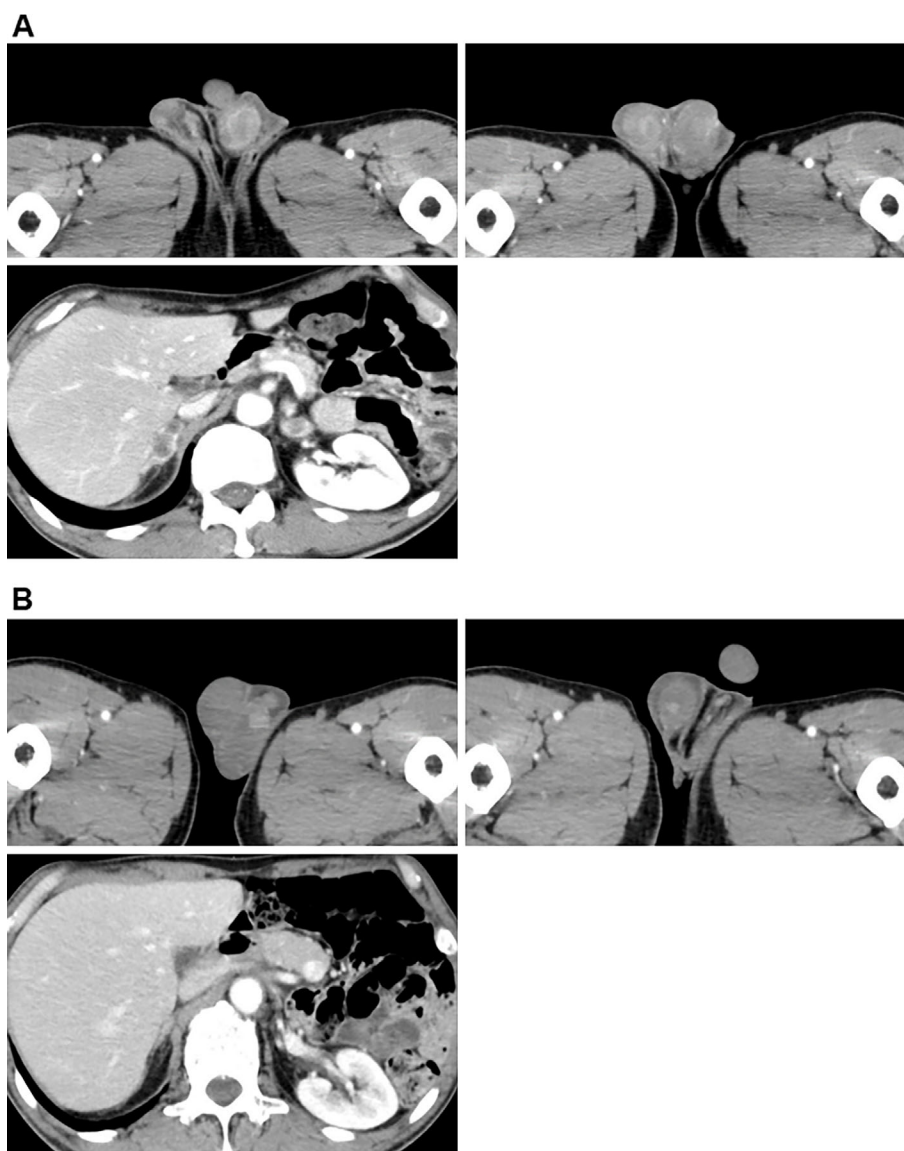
(A) A radiographic review of the patient's contrast abdominal and pelvic CT scans performed in September 2017 incidentally revealed bilateral testicular and adrenal gland masses. (B) When reviewed retrospectively, the CT scan performed in May 2017 also showed a nodular shadow involving both testes, which was presumed to indicate testicular metastasis, although adrenal metastasis was not detected on that scan.
